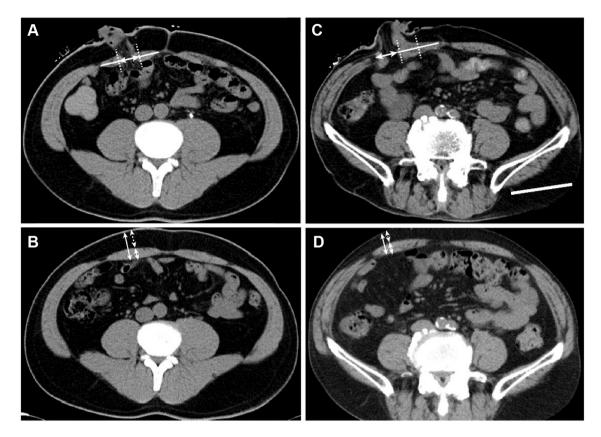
Definition of the stoma position and method for measuring the thickness of the abdominal wall. A: In this patient, the stoma ran through the middle of the rectus abdominis muscle. B: Preoperative computed tomography of the patient in part A. The thickness of the abdominal wall was measured in the middle of the rectus abdominis muscle where the stoma was created. C: In this patient, the stoma ran through the lateral side of the rectus abdominis muscle. D: Preoperative computed tomography of the patient in part C. The thickness of the abdominal wall was measured on the lateral side of the rectus abdominis muscle where the stoma was created.
